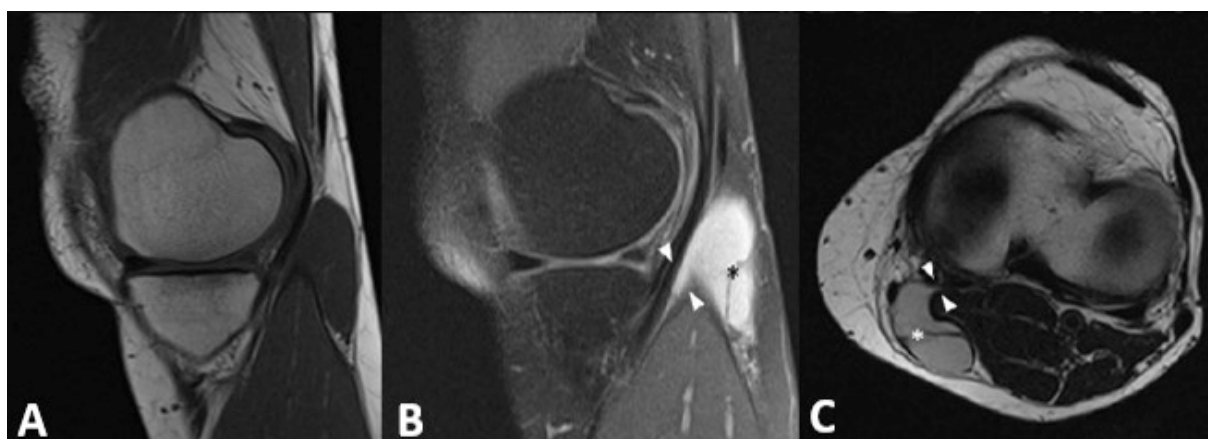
MRI sagittal spin echo-T1w (A), turbo spin echo-T2w Fat Sat (B) and axial turbo spin echo-T2w (C) images. Large ovular formation, which extends from the knee posteriorly between the tendons of the medial head of the gastrocnemius and the semimembranosus, with low signal in T1w sequences and high signal in T2w, consisting in complicated Baker's cyst. Note the internal irregular septa (*) and the collar of the cyst (between the arrowheads) through which it is in communication with the joint cavity.
